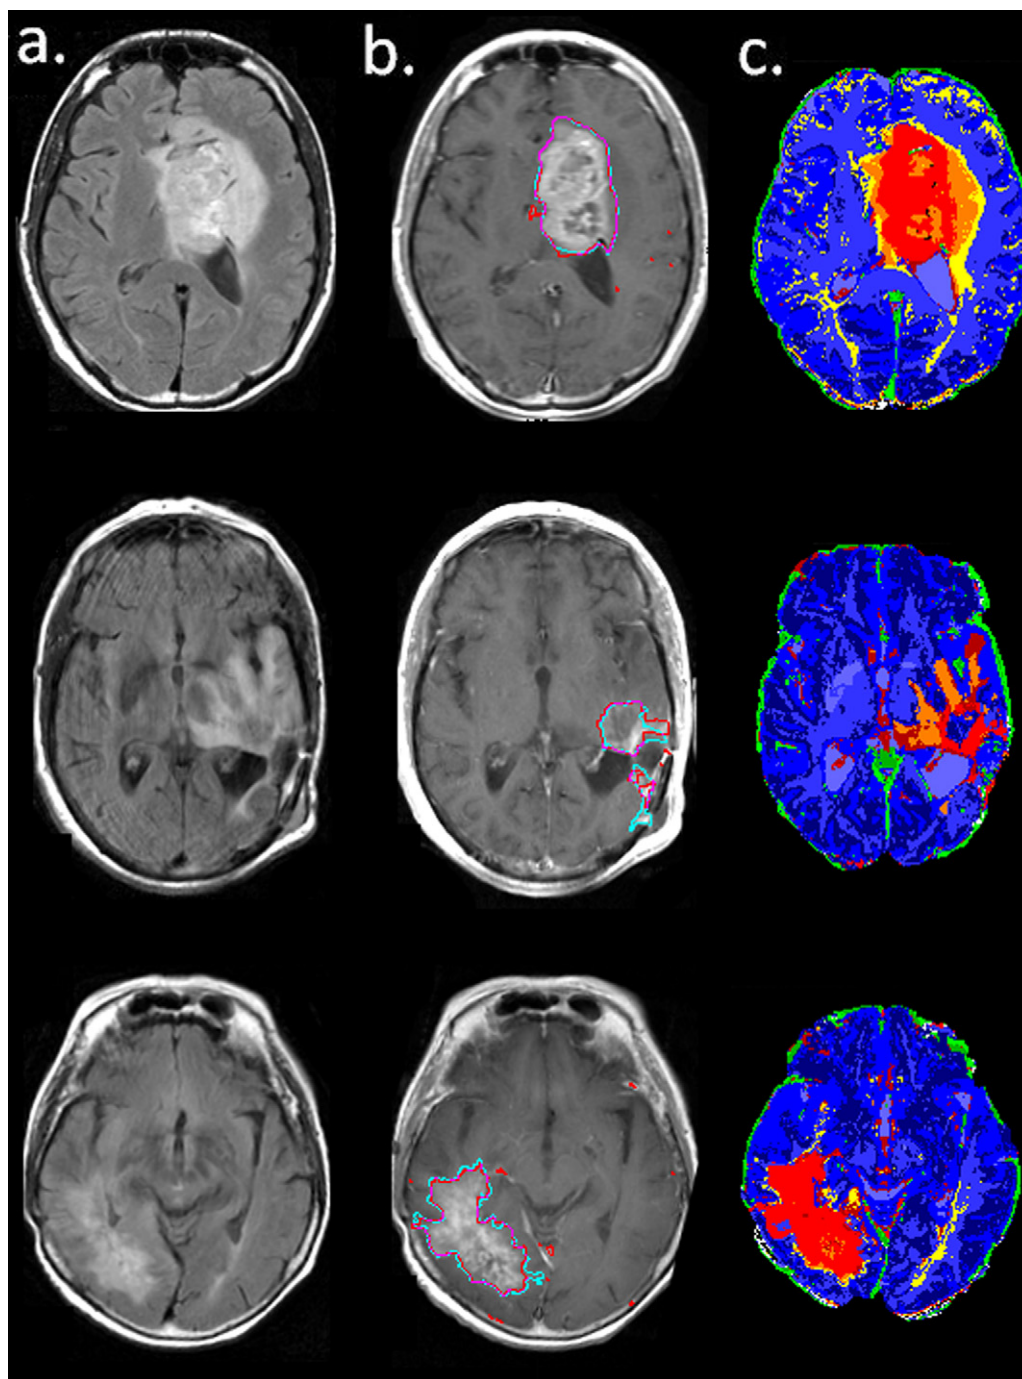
Representative results obtained from three patients (#6, 11, 12): FLAIR Images – first column; contrast-enhanced SPGR T1 WI overlaid with the kNN (red) and manual (turquoise) delineation of the enhancing tumor (violet color represents the area with overlapping signs) – second column; the kNN tissue classification results – third column. The 11 classes are marked with: light red ■ – enhancing and dark red ■ – non-enhancing tumor; orange ■ – peri-tumoral and yellow ■ – non-peri-tumoral edema; dark blue ■ – deep GM; blue ■ – cortical GM; light blue ■ WM, and ■ CSF; white □ – skull; dark green ■ – arteries and light green ■ – veins.
